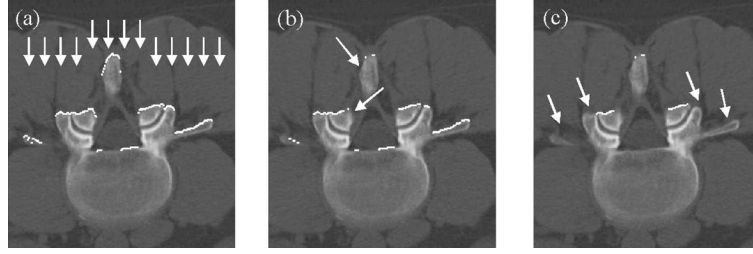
(a) CT slice and all bone surface points that can be seen from dorsal, the arrows show the assumed direction of the sound propagation. (b) Estimation of the bone surface points that can be visualized by the ultrasound, the arrows mark the parts of the surface where the surface points were eliminated. (c) Surface after manual separation of one vertebra, the arrows mark the parts of the surface which belong to a neighboring vertebra.
